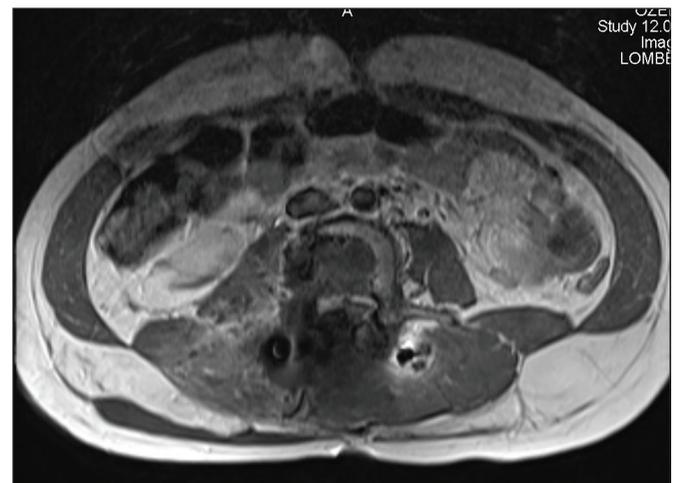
Post-operative axial MRI image with contrast.
